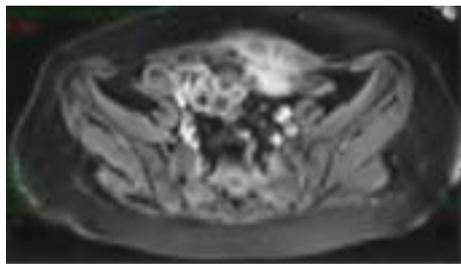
MRI: an imprecise contoured image, 94.1/76.1/47.5 mm in dimensions with hipo/hipersignal at the T1, T2 and TIRM levels with muscular fibres continuity interruption on the left rectus abdominis muscle at 7 cm from the distal insertion. It was also found a diffuse interstitial oedema at the level of the left side of rectus abdominis muscle and partially at the level of the right side of rectus abdominis muscle, having the aspect of haematic infiltration
